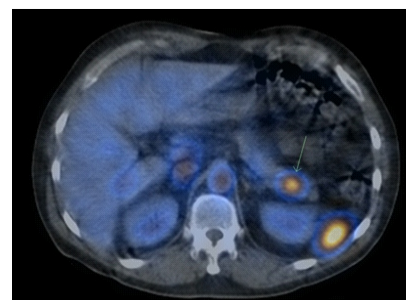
Axial fused SPET/CT image of $^{99\text{m}}\text{Tc}$ -HDRBC scan confirming functioning splenic tissue within the pancreatic tail and concordant with the focal PSMA uptake seen on the PET/CT
